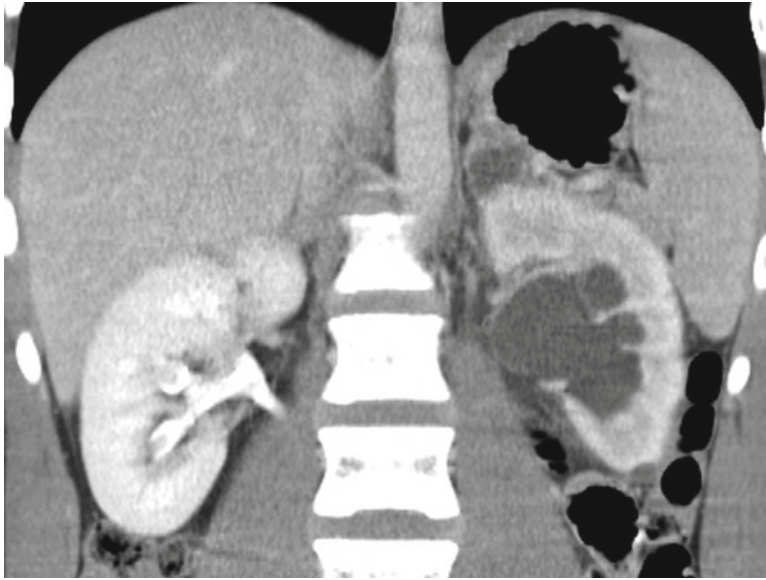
Coronal CT image of left ureteropelvic junction obstruction. Note the absence of contrast in the dilated left calyces and renal pelvis
